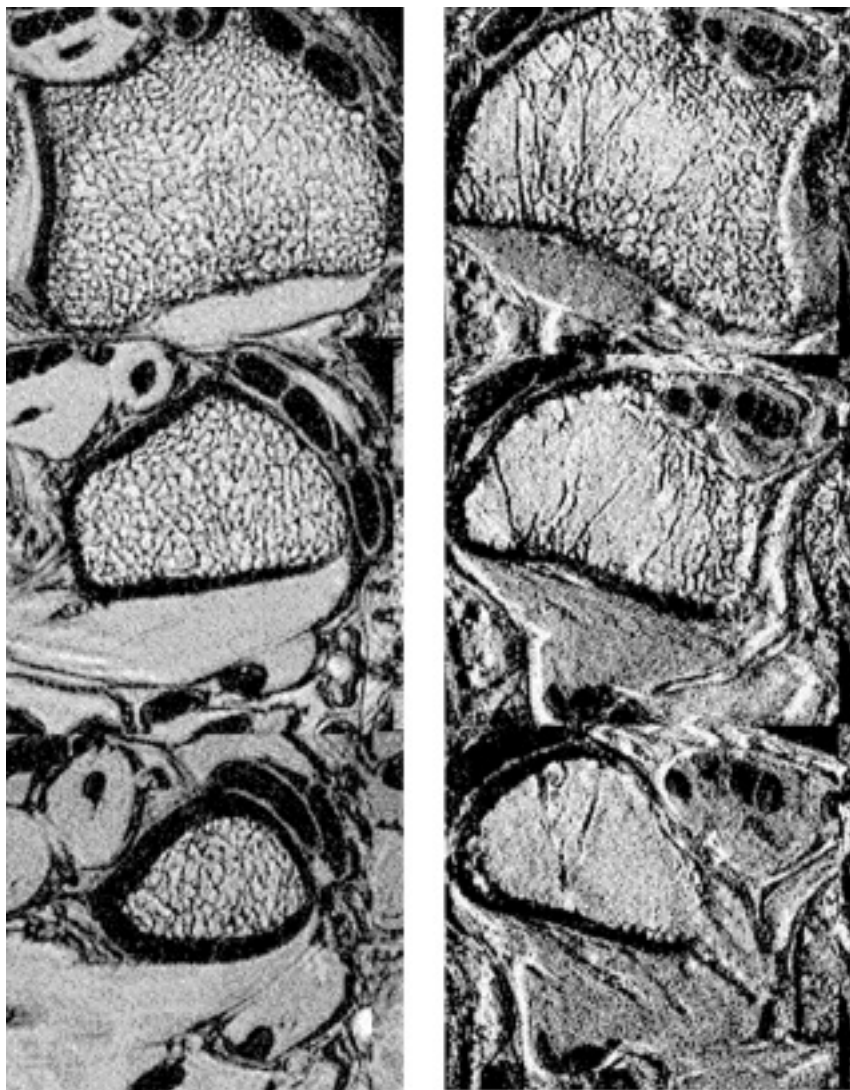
High-resolution ($\sim 150 \times 150 \times 500 \mu\text{m}$) axial gradient echo MR images of the distal radius of a young woman (L) and an elderly osteoporotic woman (R) clearly show the deterioration in trabecular and cortical structure. (Courtesy of Sharmila Majumdar.)
